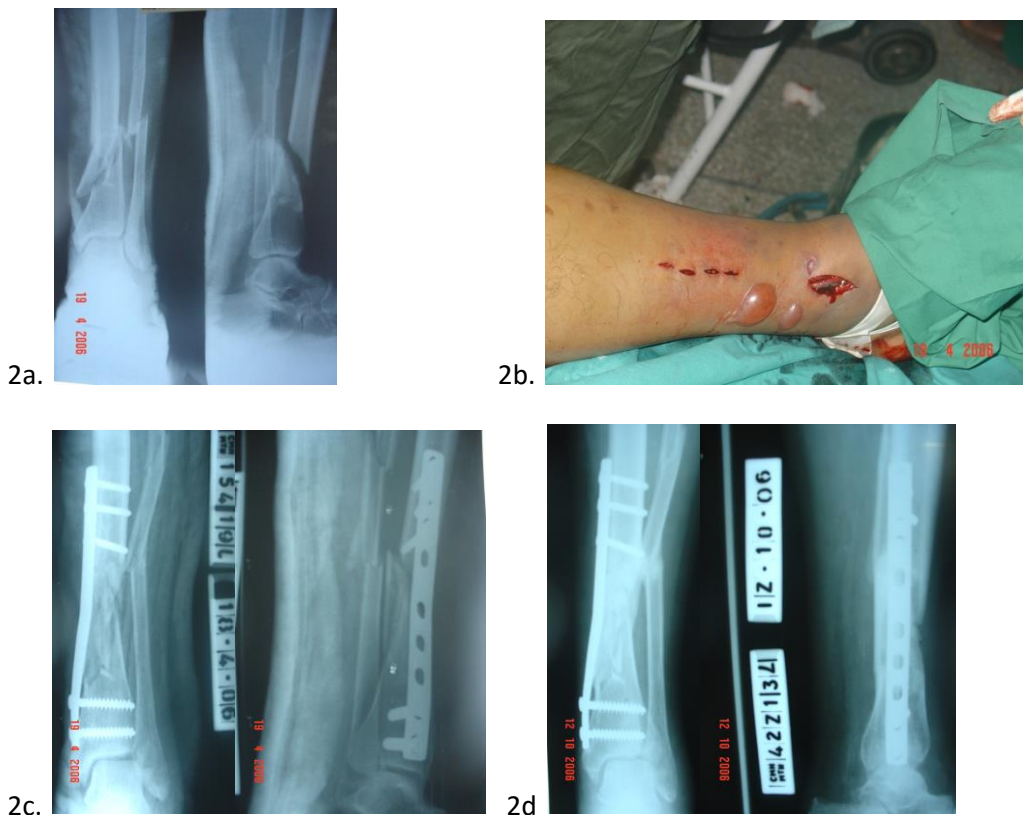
(a) Comminuted fracture distal tibia Type A3. (b) Per-operative photograph showing small MIPO incisions. Note the fracture blisters on the skin around fracture. (c) Post-op X-rays (AP and Lateral views). (d) Consolidated fracture union is seen at 24 weeks.
